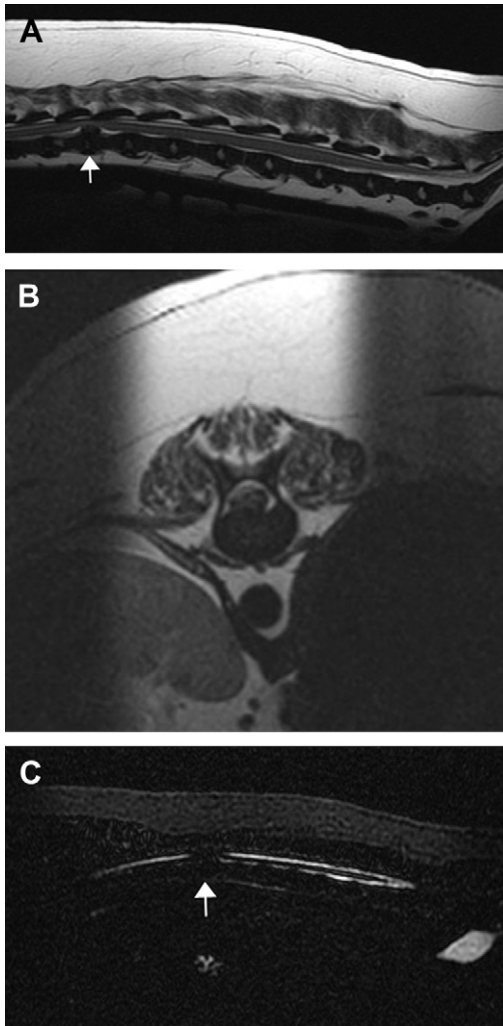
Sagittal (A) and transverse (B) T2-weighted MR images of an extruded disc at T12 to T13 (arrow) with evidence of disc degeneration at T10 to T11, T11 to T12, T12 to T13 and T13 to L1. Heavily weighted T2 sequence (MR myelogram) showing the absence of CSF signal ventrally and dorsally at T12 to T13 (arrow) (C).
